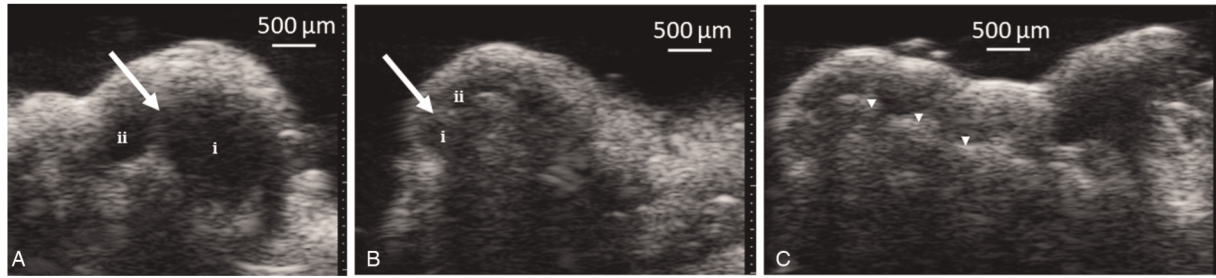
2D ultrasound of the cochlea. *A*, Visualization of the basilar membrane (BM) (white arrow), scala tympani (ST) (i) and scala vestibuli (SV) (ii) at the base of the cochlea. *B*, Visualization of the BM (white arrow), ST (i), SV (ii) at the apex of the cochlea. *C*, Longitudinal view of the modiolus all along the cochlea (white arrowheads).
